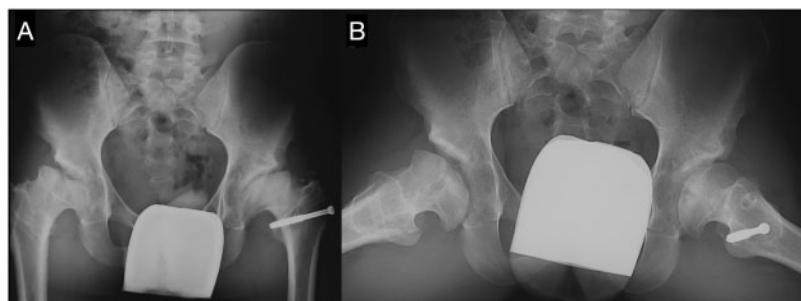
Anteroposterior pelvic radiograph (A) and axial view of both hips (B) at the last follow-up at 4 and 5 years post-operatively. The findings are similar to the ones in previous radiographs but with all of the screws already extracted except for the left lower one. Radiological signs of healing of the osteochondral lesion are evident in the left hip, while in the right hip the central osteochondral lesion is still partially visible. Extrusion index has improved, as well as LCEA, however, there is residual adaptive acetabular dysplasia.
